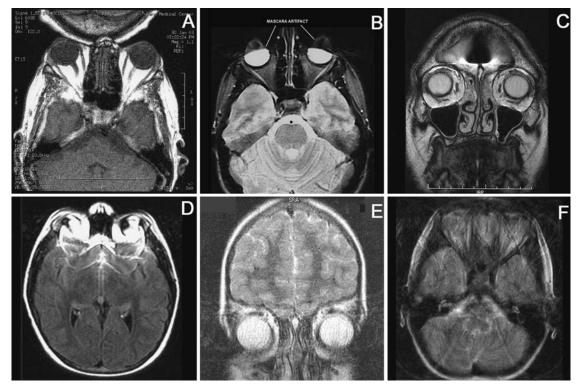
MRI artifacts. (A) Wraparound artifact due to wrong field of view. (B) Distortion because of the iron pigment in patient's mascara. (C) Surgical clip results in distortion or shielding of magnetic field. (D) Metal artifact (dental hardware). (E) Ghosting from orbital motion. (F) Distortion due to head motion.
